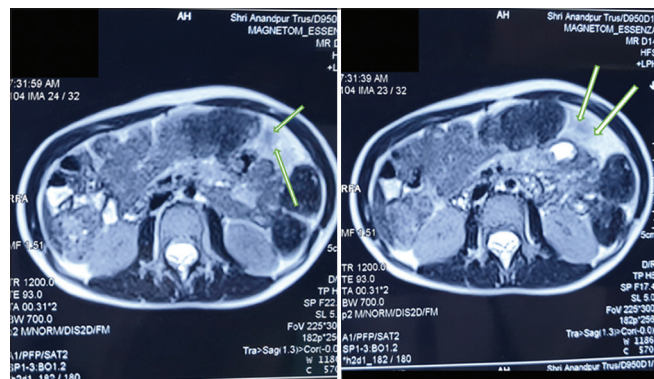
Confirmation of free peritoneal fluid on contrast-enhanced magnetic resonance imaging (arrow)
